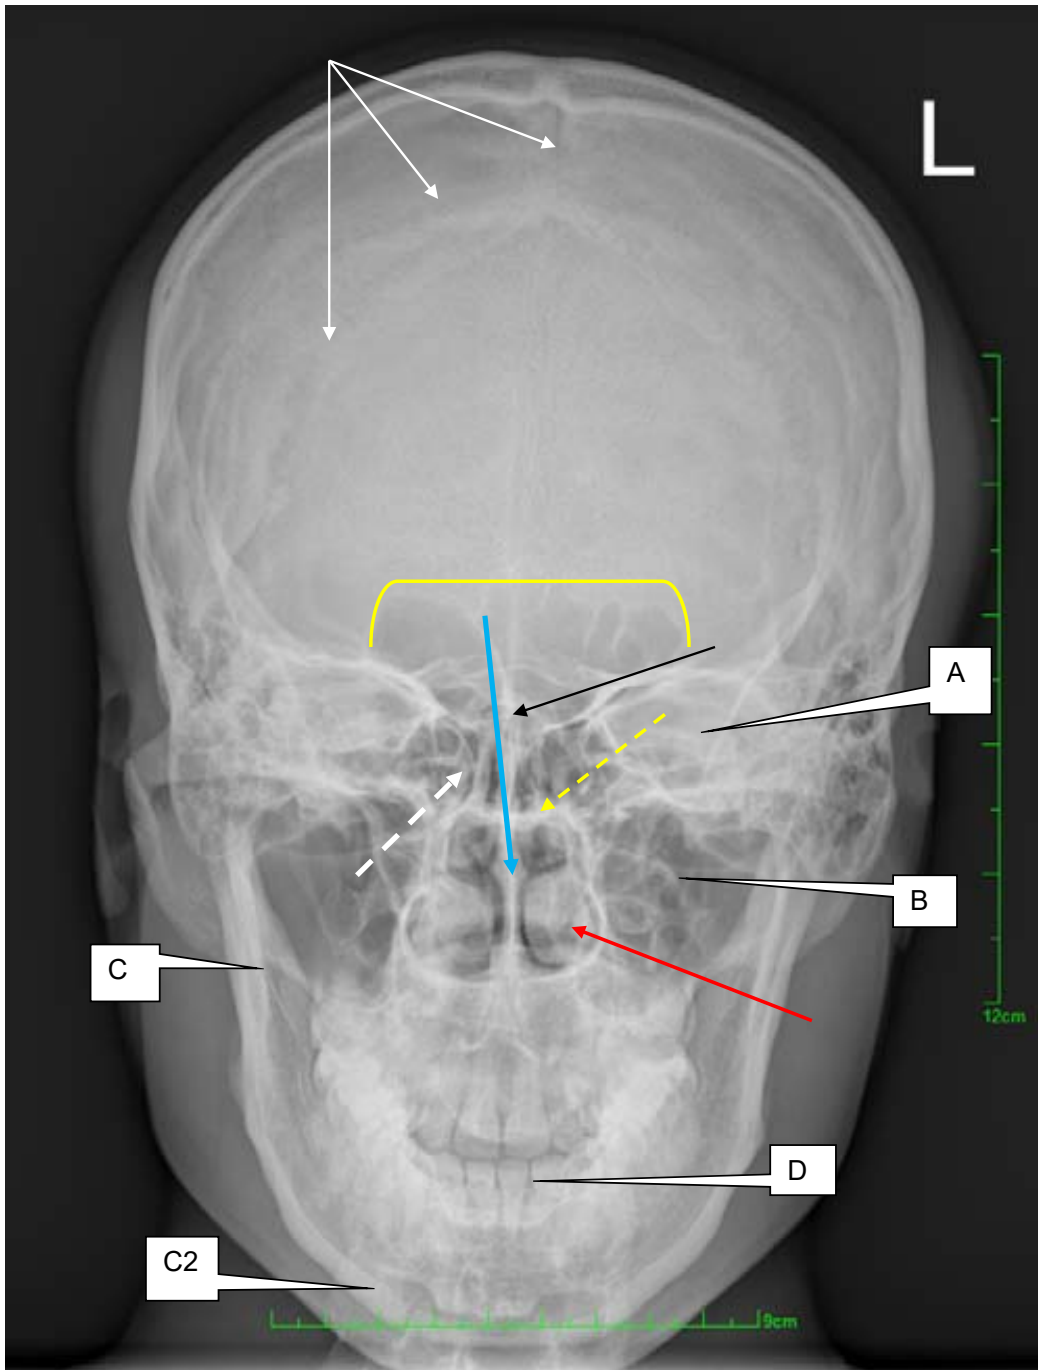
An anteroposterior (AP) radiograph of the skull.
